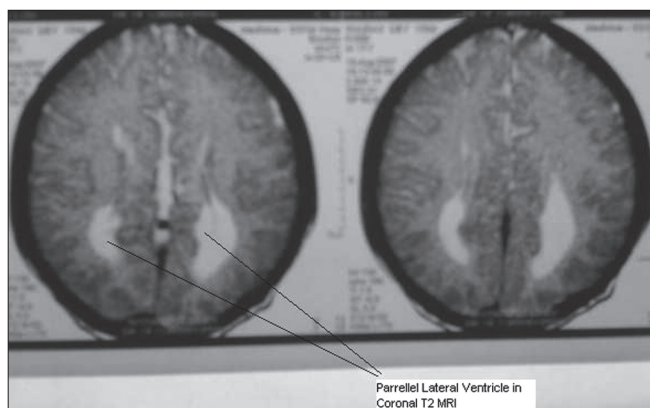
Coronal T2 MRI of the patient showing agenesis of corpus callosum with parallel lateral ventricles
